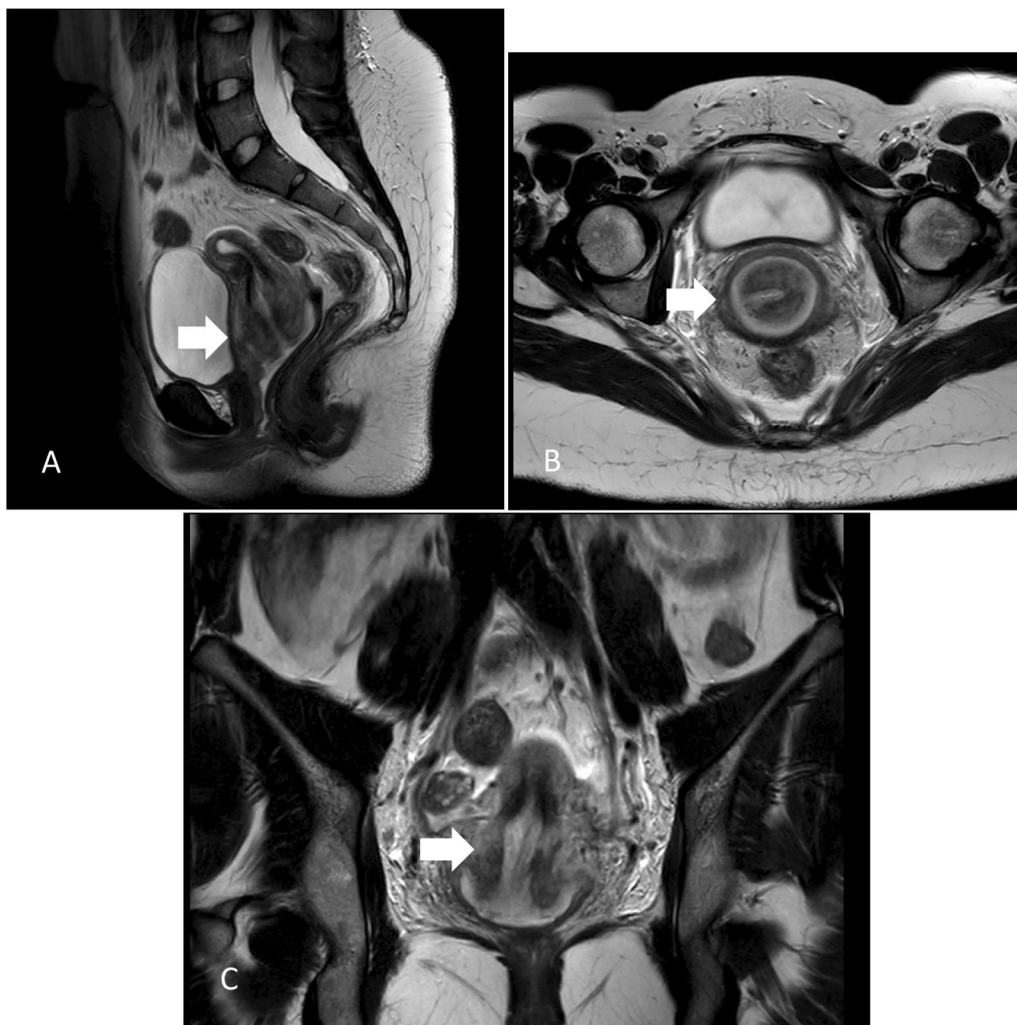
T2-weighted magnetic resonance (MR) images showing significant cervical swelling and edema on (A) sagittal, (B) transverse, and (C) coronal views (white arrows)
